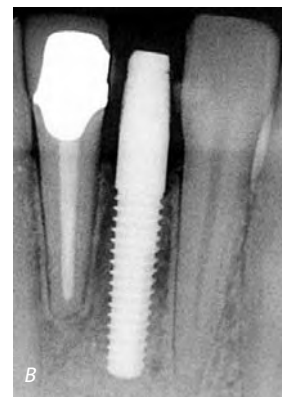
A, One-piece implant, temporary crown removed; B, radiograph.
